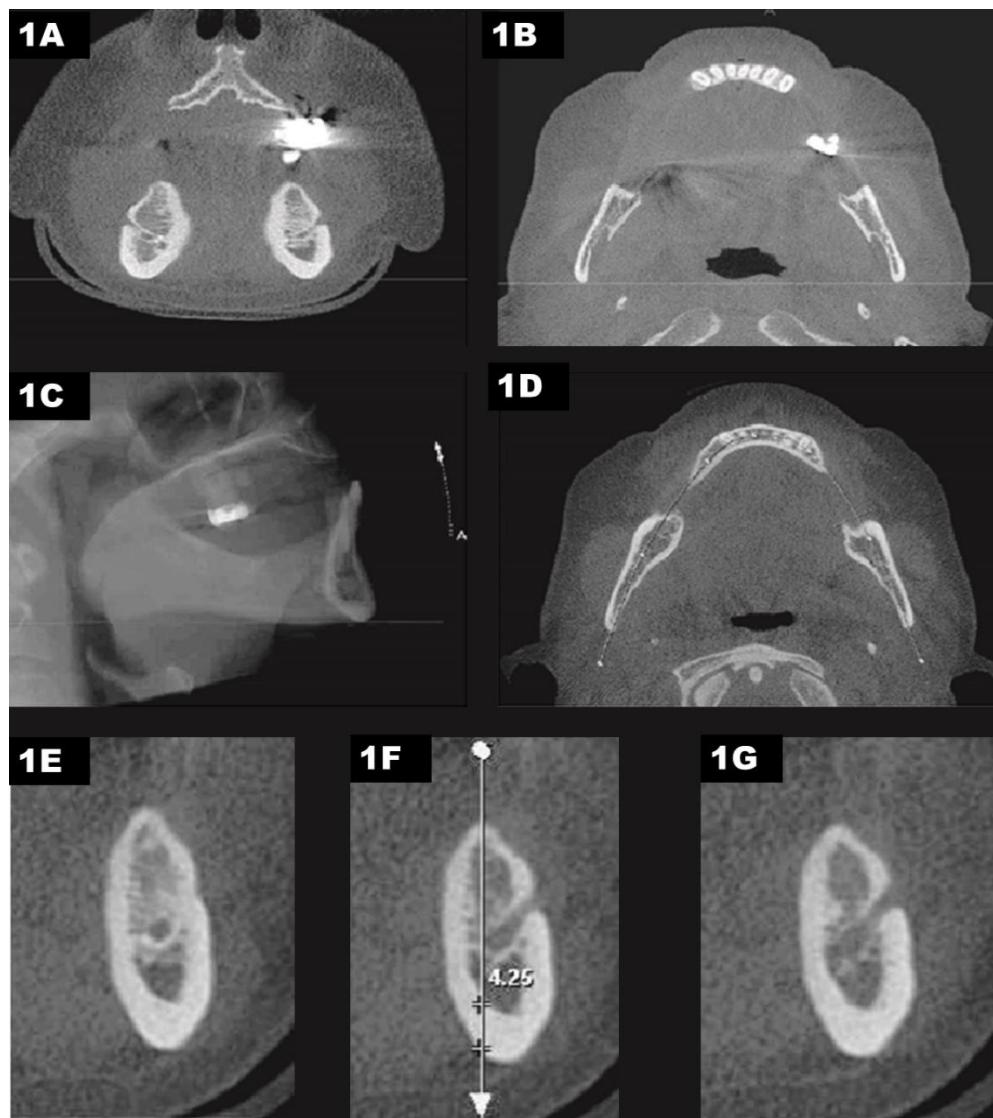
Standardization on CBCT sections to measure MCW.
